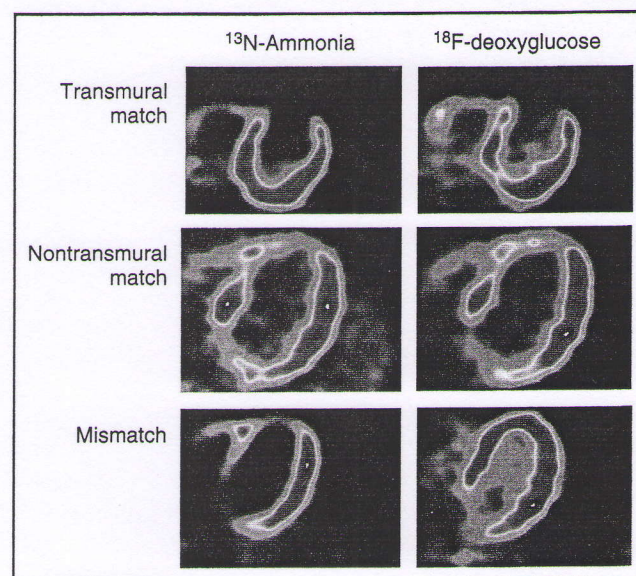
Regional myocardial perfusion (as evaluated by ^{13}N -ammonia) compared with ^{18}F -deoxyglucose (FDG) uptake in types of clinical situations. There may be concordant uptake of both tracers (the so-called perfusion metabolism "match" pattern), which may be categorized as transmural match (absent or markedly reduced perfusion and FDG uptake) or nontransmural match (mildly to moderately reduced perfusion and FDG uptake). The third pattern is "mismatch," which is typical for hibernating myocardium (reduced perfusion and uniform glucose uptake). See also Color Insert.
